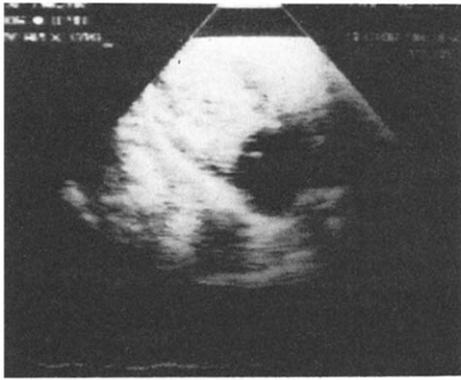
Two-dimensional echocardiographic image of a left ventricular contrast injection during normal sinus rhythm (NSR). There is no evidence of mitral regurgitation. LA = left atrium; LV = left ventricle; MV = mitral valve.
